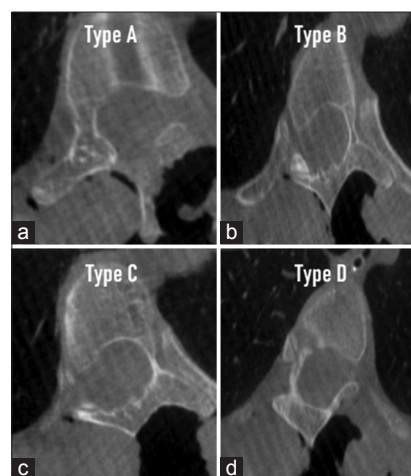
Watanabe *et al.* computed tomography-based pedicle channel classification, (a) Type A: a “large cancellous channel,” (b) Type B: a “small cancellous channel,” (c) Type C: a “cortical channel,” and (d) Type D: a “slit/absent pedicle channel.”
